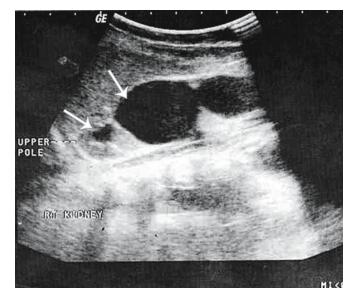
Ultrasound scan shows the duplex system (arrows) with a grossly dilated lower moiety
